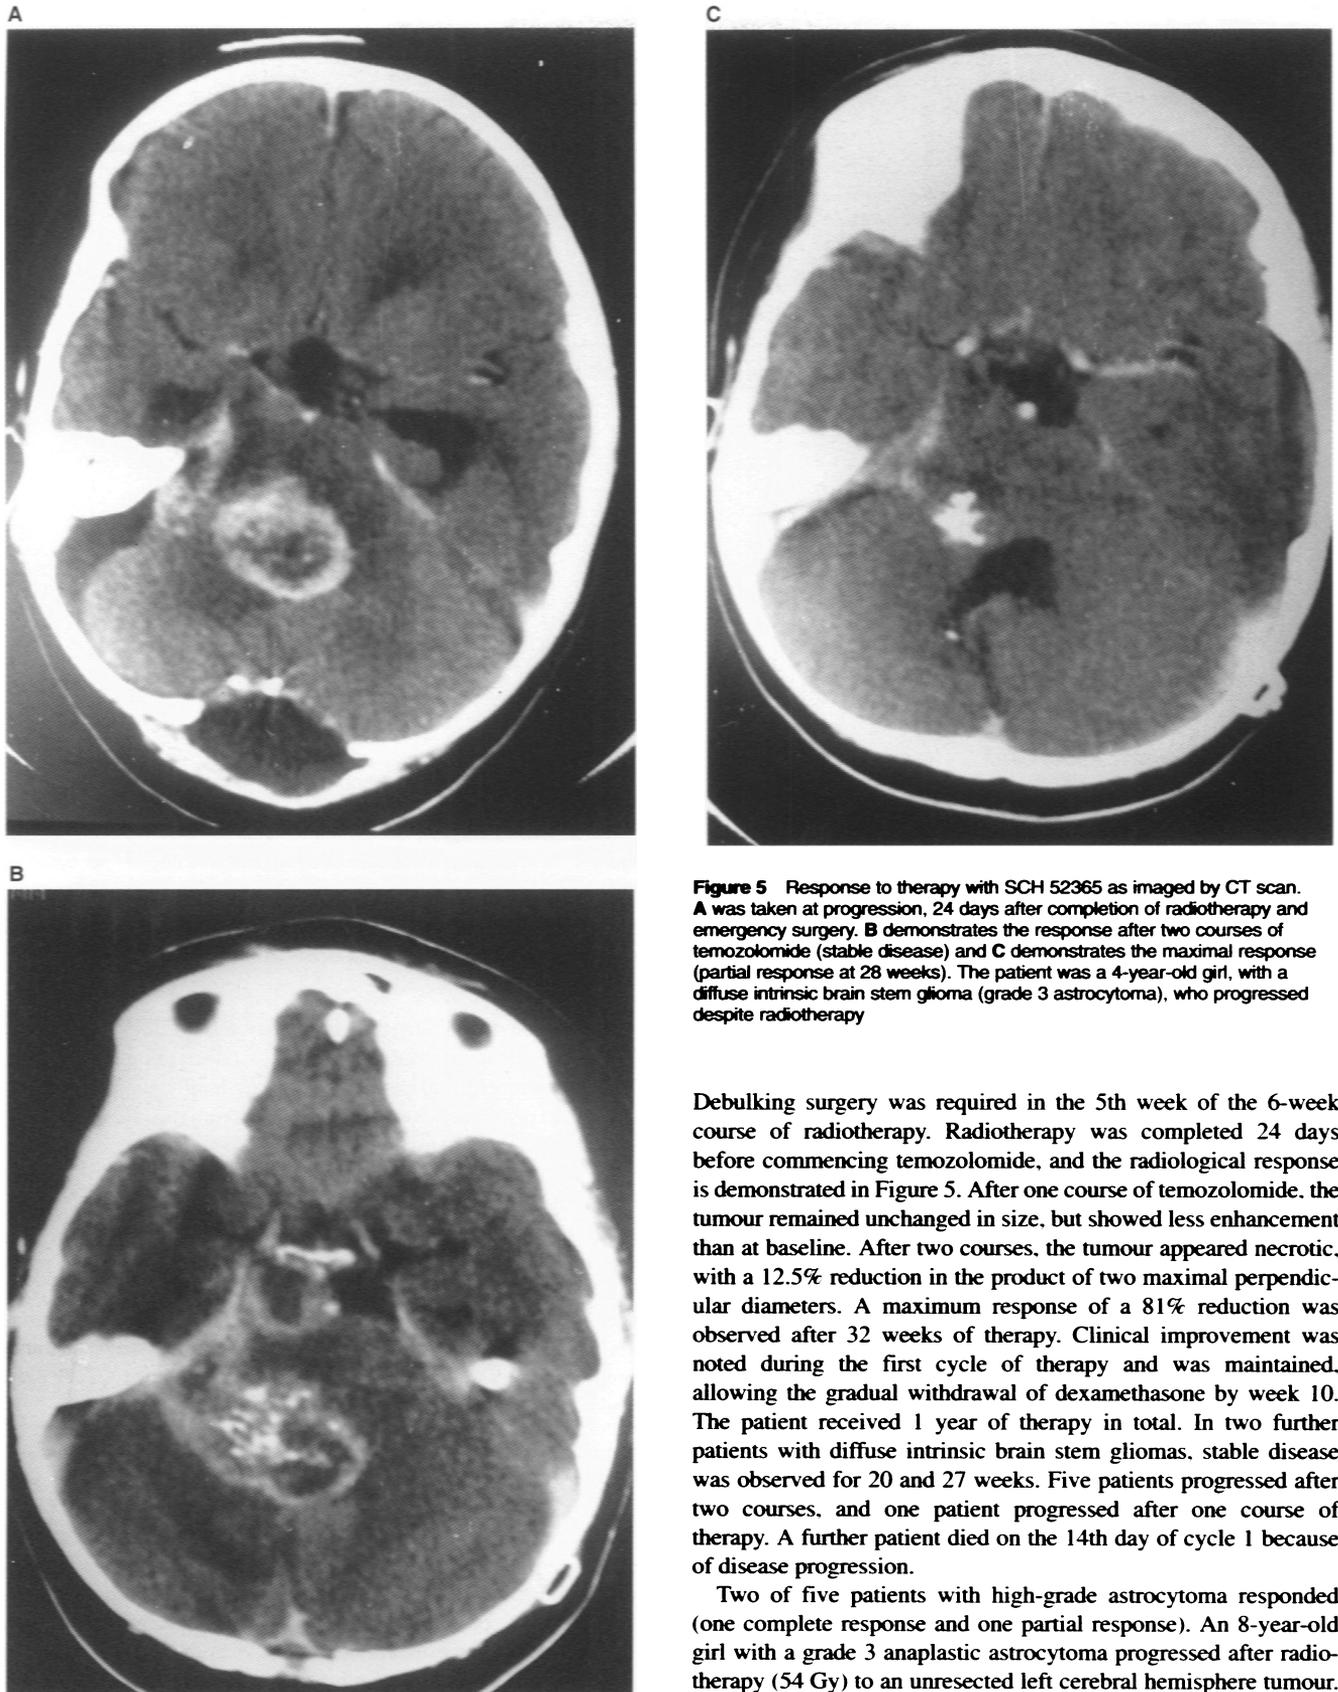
Response to therapy with SCH 52365 as imaged by CT scan. A was taken at progression, 24 days after completion of radiotherapy and emergency surgery. B demonstrates the response after two courses of temozolomide (stable disease) and C demonstrates the maximal response (partial response at 28 weeks). The patient was a 4-year-old girl, with a diffuse intrinsic brain stem glioma (grade 3 astrocytoma), who progressed despite radiotherapy
